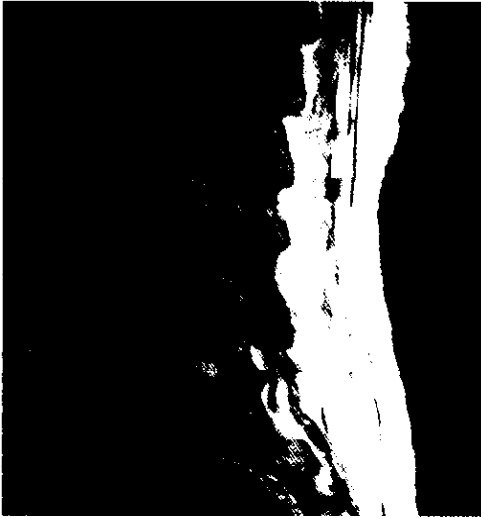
Sagittal lumbar MRI showing multiple well defined vertebral haemangiomas in L3 and L5 vertebral bodies
